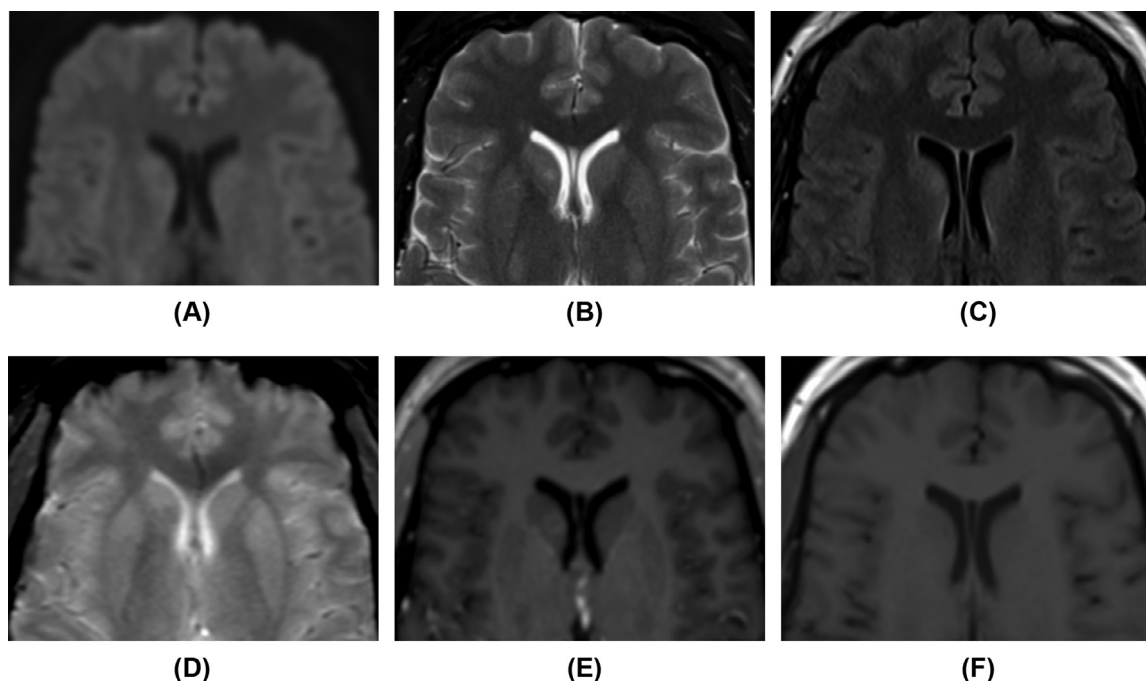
Initial 1.5T MRI obtained 2 months after presentation demonstrate an enhancing 6 mm right caudate head lesion with (A) no restricted diffusion. The lesion is minimally (B) T2 and (C) T2-FLAIR hyperintense without surrounding edema or mass effect. (D) On GRE sequence there was mild associated signal loss. (E) The lesion demonstrates rim-enhancement on post contrast T1-weighted imaging, compared to (F) isointense to minimally hypointense on pre-contrast imaging. One-month follow-up imaging on a 1.5T MRI was essentially unchanged (not shown).
